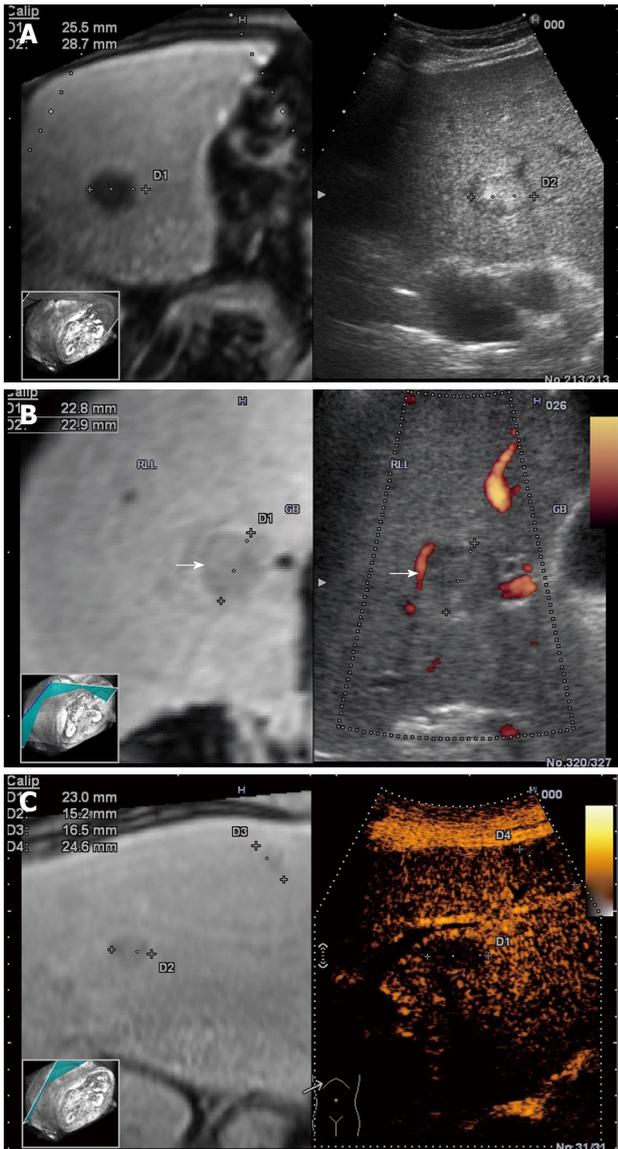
Real-time virtual sonography of liver nodules with simultaneous display of the contrast-enhanced magnetic resonance section and ultrasound images. 2D (A), Power Doppler (B), and contrast enhanced ultrasound (C) vs the reconstructed corresponding image.
